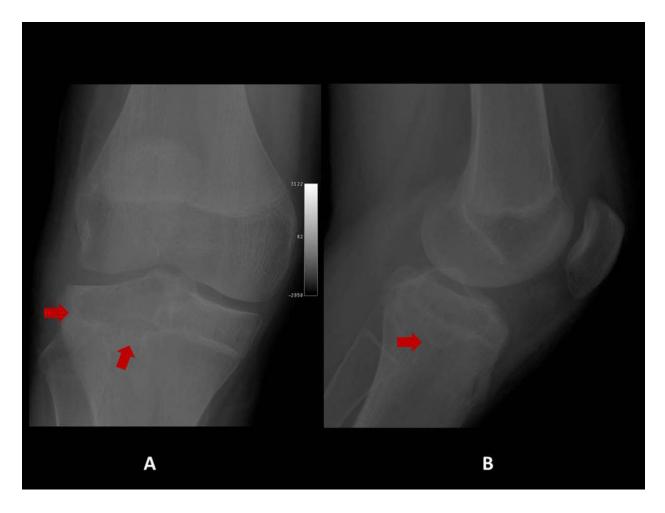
Chondroblastoma. Anterior-posterior (A) and lateral (B) radiographs of the right knee reveal a well-demarcated lytic lesion in the proximal epiphysis of the right tibia surrounded by a thin sclerotic rim (arrows).
